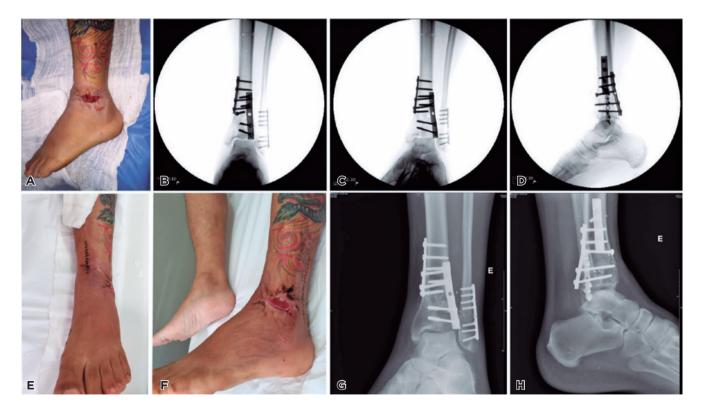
Second stage. A) Photographic image with an improvement of the lateral wound after removal of the external fixator. B-D) Fluoroscopic images in the anteroposterior, mortise, and lateral views of the ankle observing the fixation method of the posterolateral fragment of the tibia and fibula through a posterolateral ankle approach. E-F) Photographic images at two weeks after surgery showing wounds without inflammation with progressive improvement of the edema. G-H) Radiographic images in mortise and lateral views of the ankle at four weeks after surgery demonstrating bone healing with anterolateral osteochondral failure.
